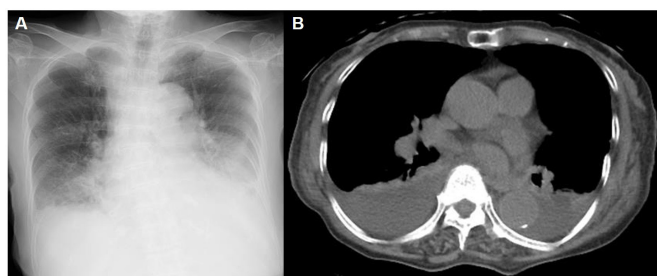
Pleural effusion after mRNA vaccination in case 1. Chest X-ray (A) and chest CT (B) showed bilateral pleural effusions.
